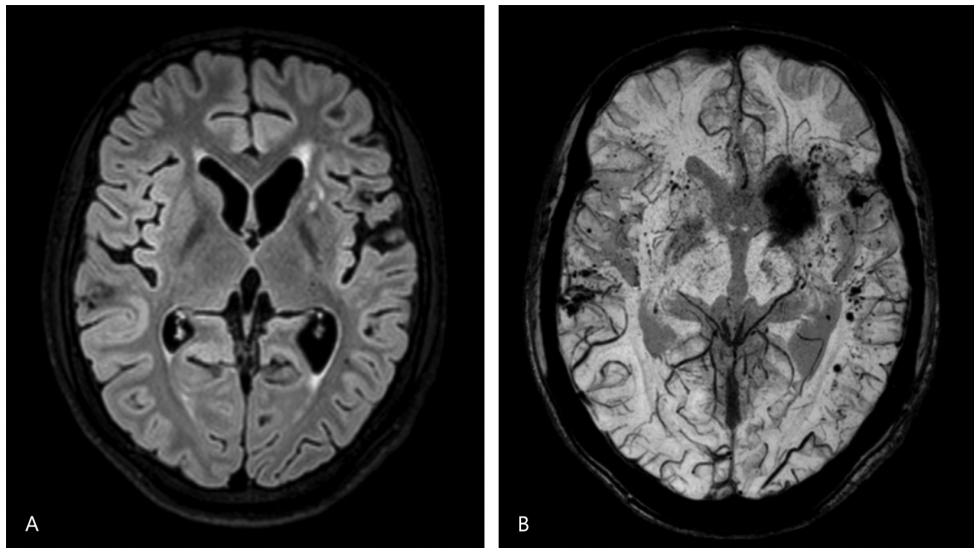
(A) Magnetic resonance imaging (MRI) brain revealing T2-FLAIR (fluid-attenuated inversion recovery) hyperintensities in the left frontal lobe. (B) Susceptibility-weighted imaging sequence of MRI brain showing multiple microbleeds.
